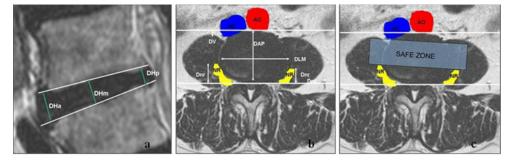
MRI measurements a Measurements of intervertebral disc space height (anterior, middle, and posterior) b Measurement of vertebral endplate diameter (*DAP* sagittal diameter, *DLM* transversal
